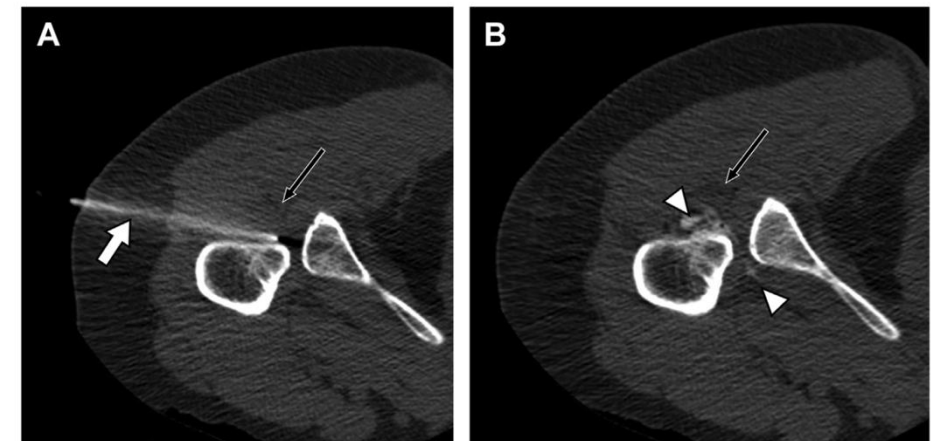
A 62-year-old-female with chronic left hip pain and IF space narrowing. Prone low-dose CT axial images show (A) lateral needle approach to IF space (*white arrow*), passing anterior to the sciatic nerve (*long black arrow*). (B) After injection, cortisone and contrast mixture are noted within the IF space (*arrowheads*).
